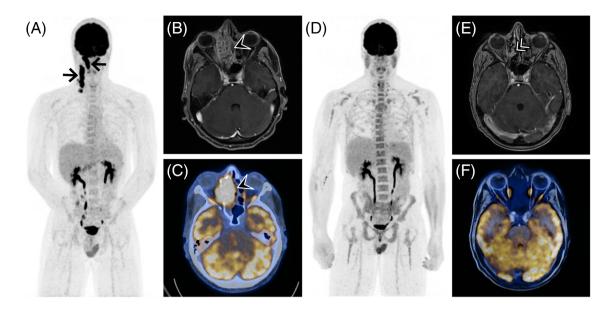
Thirty-five-year-old male patient with olfactory neuroblastoma. Initial FDG-PET/CT staging examination with synchronous MRI of the paranasal sinus and neck: (A) Whole-body maximum intensity projection (MIP) shows numerous, metabolically active lymph node metastases (black arrow). (B) Axial contrast-enhanced, fat-suppressed T1-weighted image and (C) fused FDG-PET/CT image show the FDG-avid tumor in the right-sided ethmoid with orbital infiltration (black arrow). FDG-PET/MRI restaging examination with synchronous sinonasal/neck MRI after 3 cycles of induction chemotherapy: (D) Whole-body MIP shows no distant metastasis, (E) axial contrast-enhanced, fat-suppressed T1-weighted MR image shows an unclear contrast enhancing structure in the right-sided nasal cavity (white double arrow). In (F) fused axial FDG-PET/MRI the structure is not metabolically active and thus rather consistent with scar tissue. The patient consecutively underwent transnasal-transcribriform tumor resection, with small vital remnants of olfactory neuroblastoma in the middle nasal turbinate. FDG-PET/CT, 2-[¹⁸F]-fluorodeoxy-D-glucose positron emission tomography/computed tomography; FDG-PET/MRI, 2-[¹⁸F]-fluorodeoxy-D-glucose positron emission tomography/magnetic resonance imaging [Color figure can be viewed at wileyonlinelibrary.com]
